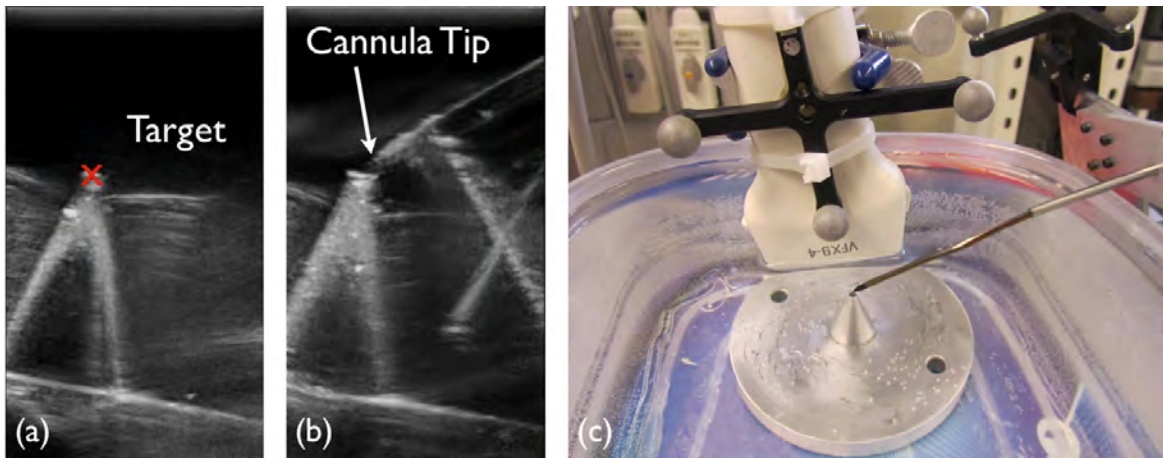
(a) Ultrasound image showing the selected target, i.e. the tip of the aluminum cone. (b) Cannula shown in ultrasound approaching the target. (c) Setup of water-ethanol targeting experiment with tracked ultrasound probe and cannula inserted.
